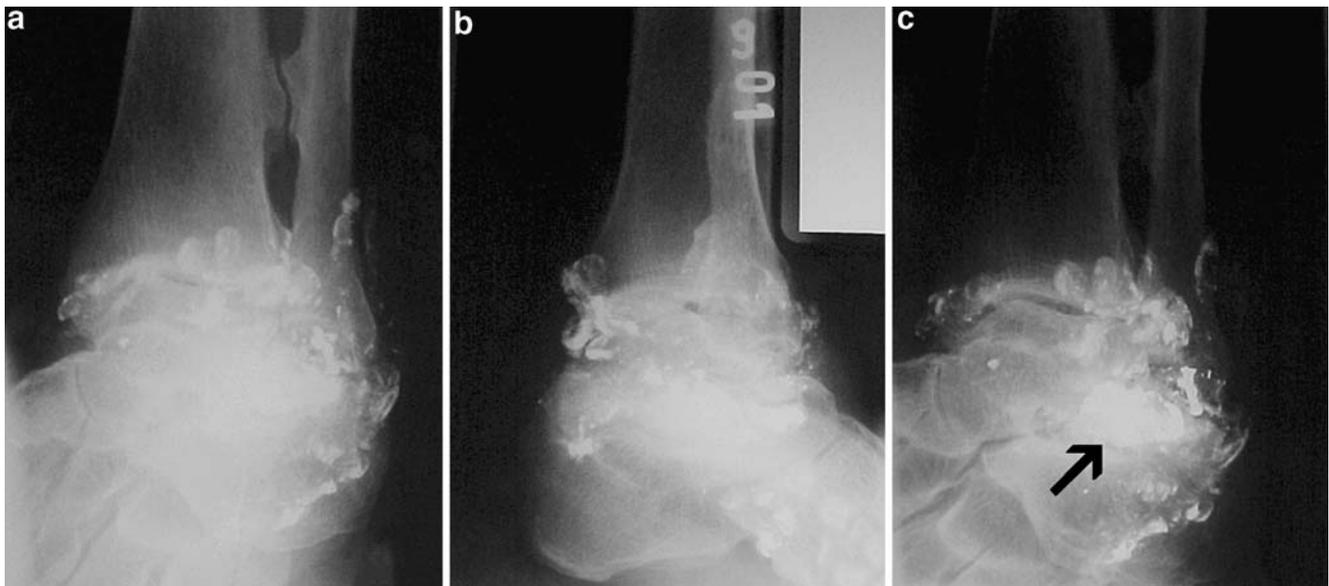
Oblique radiographs of the right ankle (case 8) reveal a deformed bullet projected over the subtalar joint, more evident in c (black arrow), asymmetric reduction of the joint spaces and a lead arthrogram with extension to the sheaths of the peroneal tendons
